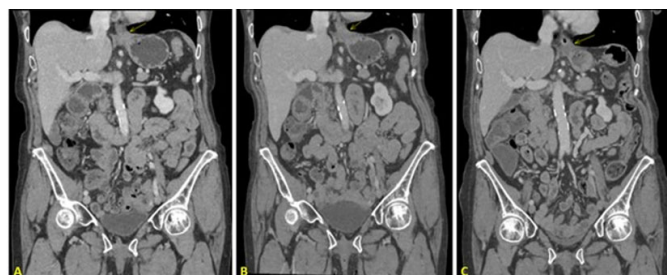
Serial CT dated January 2024 (A), October 2024 (B), and April 2025 (C), showing stable mild distal esophageal wall thickening with complete radiological resolution of the previously identified liver metastases. Biopsy from the esophageal thickening in May 2025 did not show any residual or recurrent treatment.
